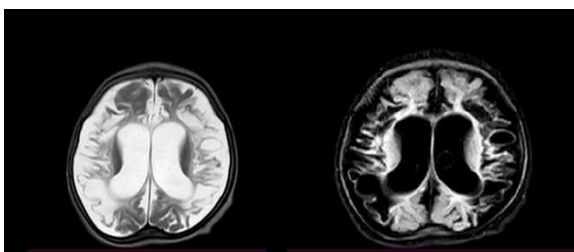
T2W and FLAIR images showing multicystic Encephalomalacia in bilateral frontoparietal lobes with brain atrophy
